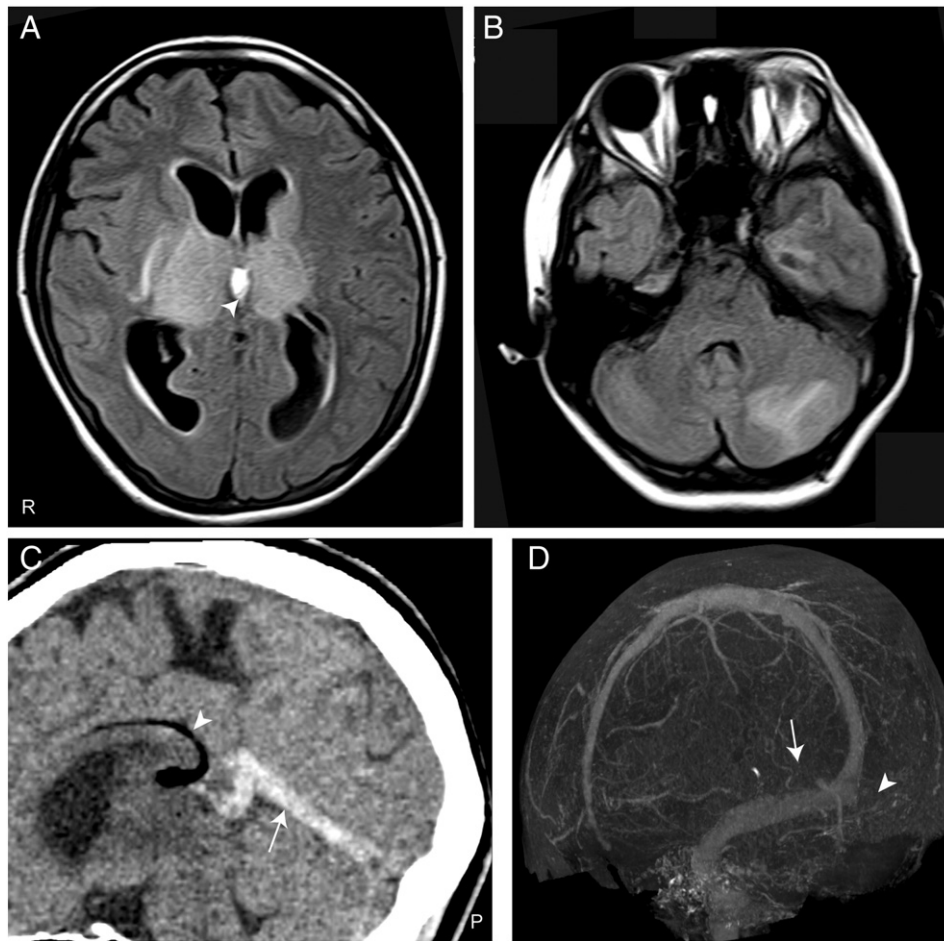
Axial MRI (A, B), sagittal CT (C), and CT venography (D) images of the patient taken on admission to hospital. Lesions with edema in the bilateral thalami (A) and left cerebellar hemisphere (B) appearing hyperintense on the fluid-attenuated inversion recovery (FLAIR) image. A mid-line lipoma (arrowhead in A). (C) A large thrombus in the vein of Galen and straight sinus (arrow). Hypointense lesion (arrowhead in C), suspicious of pericallosal lipoma, is evident. (D) Absence of flow in the straight (arrow) and left transverse (arrowhead) sinus.
